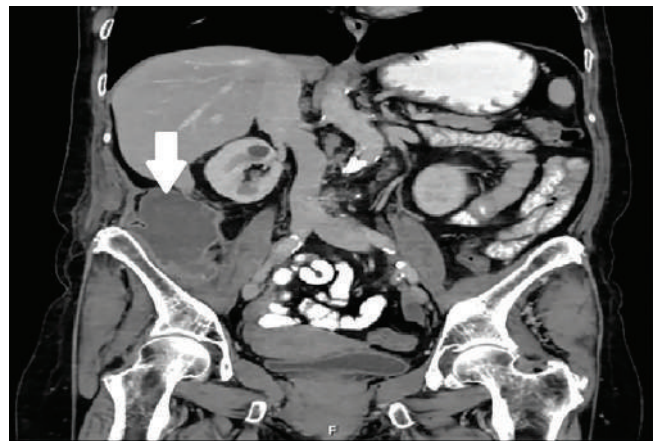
Image 1- CT imaging. Right iliopsoas abscess.
